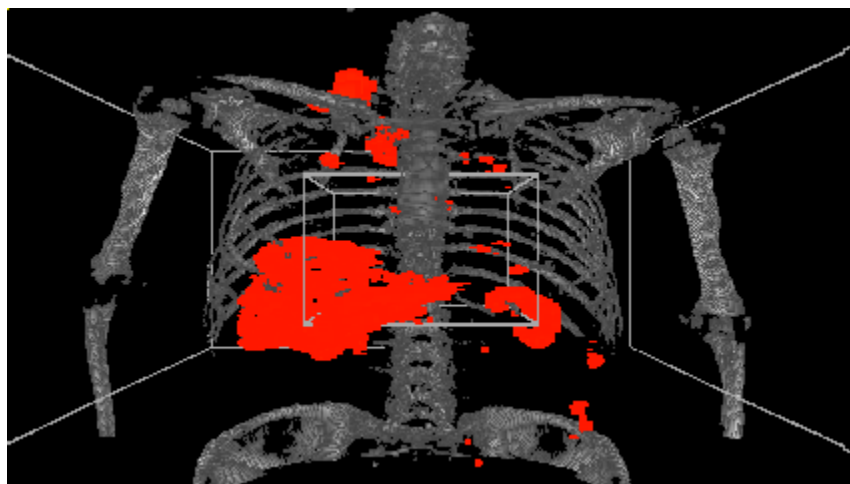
Right image with overlapping SUV projection.
